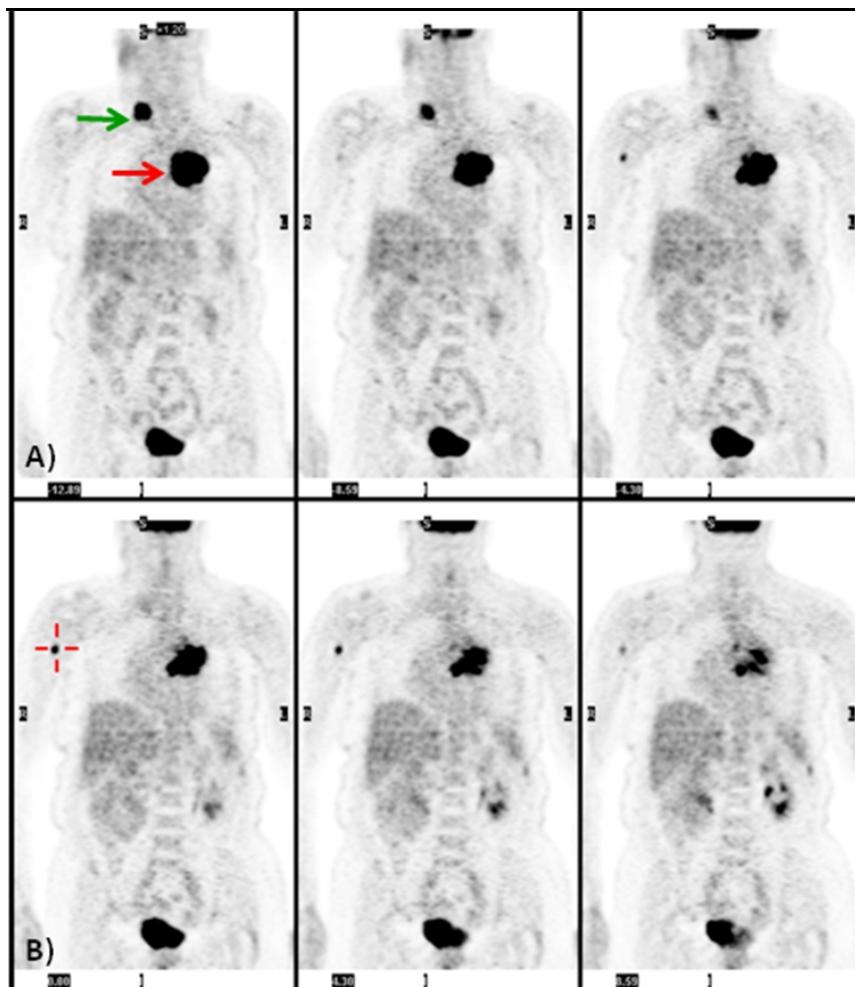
PET images in a patient with lung carcinoma. (A) ^{18}FDG PET shows the primary tumor (red arrow, 4x4.3cm, mSUV=27) with contralateral clavicle nodal metastases (green arrow, 2.7x2.5 cm, mSUV=19.2). (B) Incidental right humerus focal uptake is noted (red cross) which is suspicious for bone metastases modifying the initial disease staging from the patient to stage IV.
